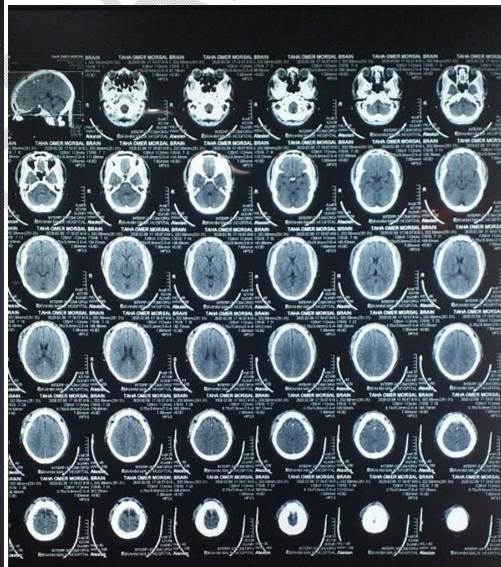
Follow up CT brain, soft tissue window showing adequate evacuation of the hematoma with relaxed brain and sinus in place.
